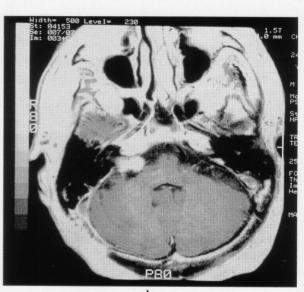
(a: sagittal, b: transaxial) MRI taken 6 months after the surgery shows the reduced tumor with a slight compression to the cerebellum and no compression to the pons.
